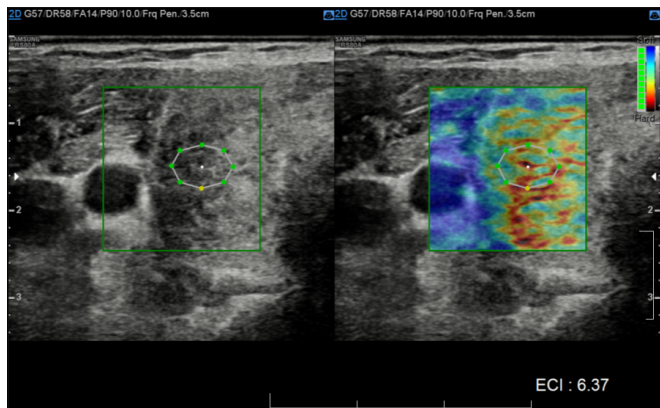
A 52 year old male patient whose ultrasound had hypoechoic nodule, ill defined margins, TI-RADS 4, Ragos criteria 4, ECI 6.3, on FNAC, it is a papillary carcinoma and bethesda category VI on FNAC
